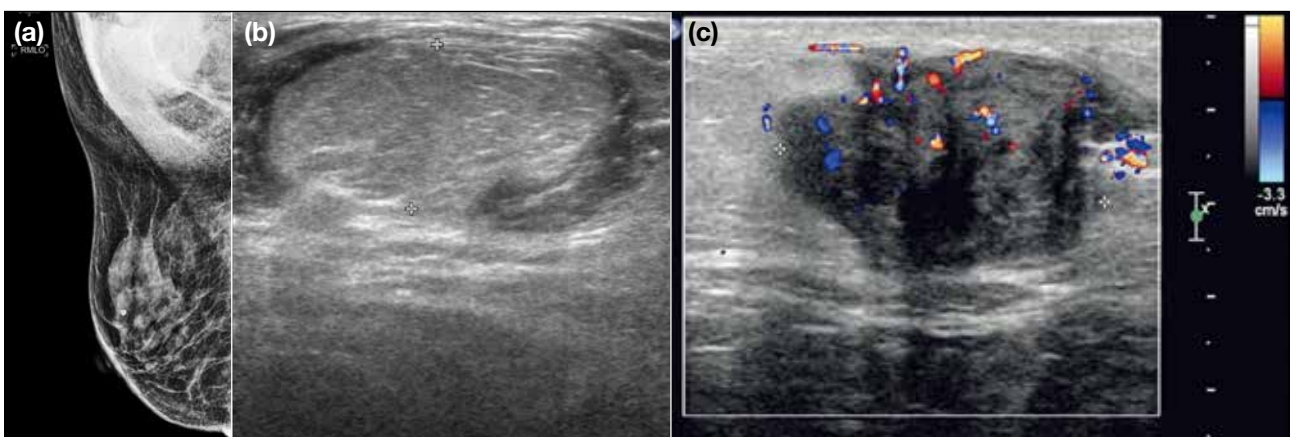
(a) Right mediolateral oblique mammogram of a 71-year-old woman who presented with a right axillary mass showing a mixed high and fat density mass at the right axilla. (b) Ultrasonography shows the lateral part of the mass as oval and parallel with obscured margin. (c) Medially, there is a more hypoechoic component with increased vascularity. In view of the fat component, liposarcoma was suspected clinically and subsequently confirmed by pathology.
